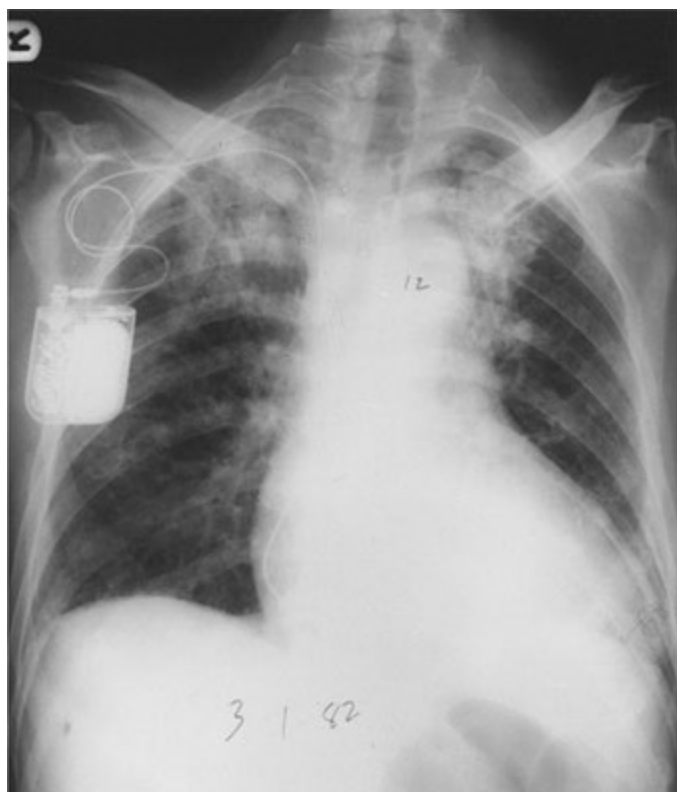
Chest radiograph of a patient with amiodarone pulmonary toxicity showing confluent alveolar shadowing in both upper lobes.
